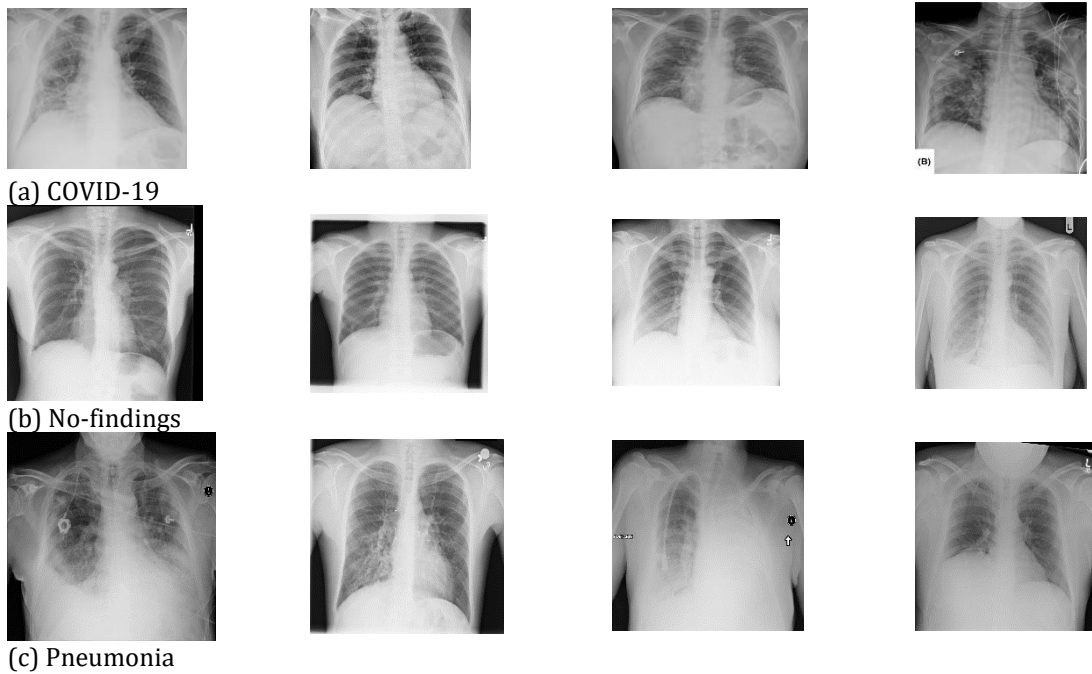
Sample images of the X-ray image dataset used for COVID-19 detection. This dataset contains COVID-19, No-findings, and Pneumonia
